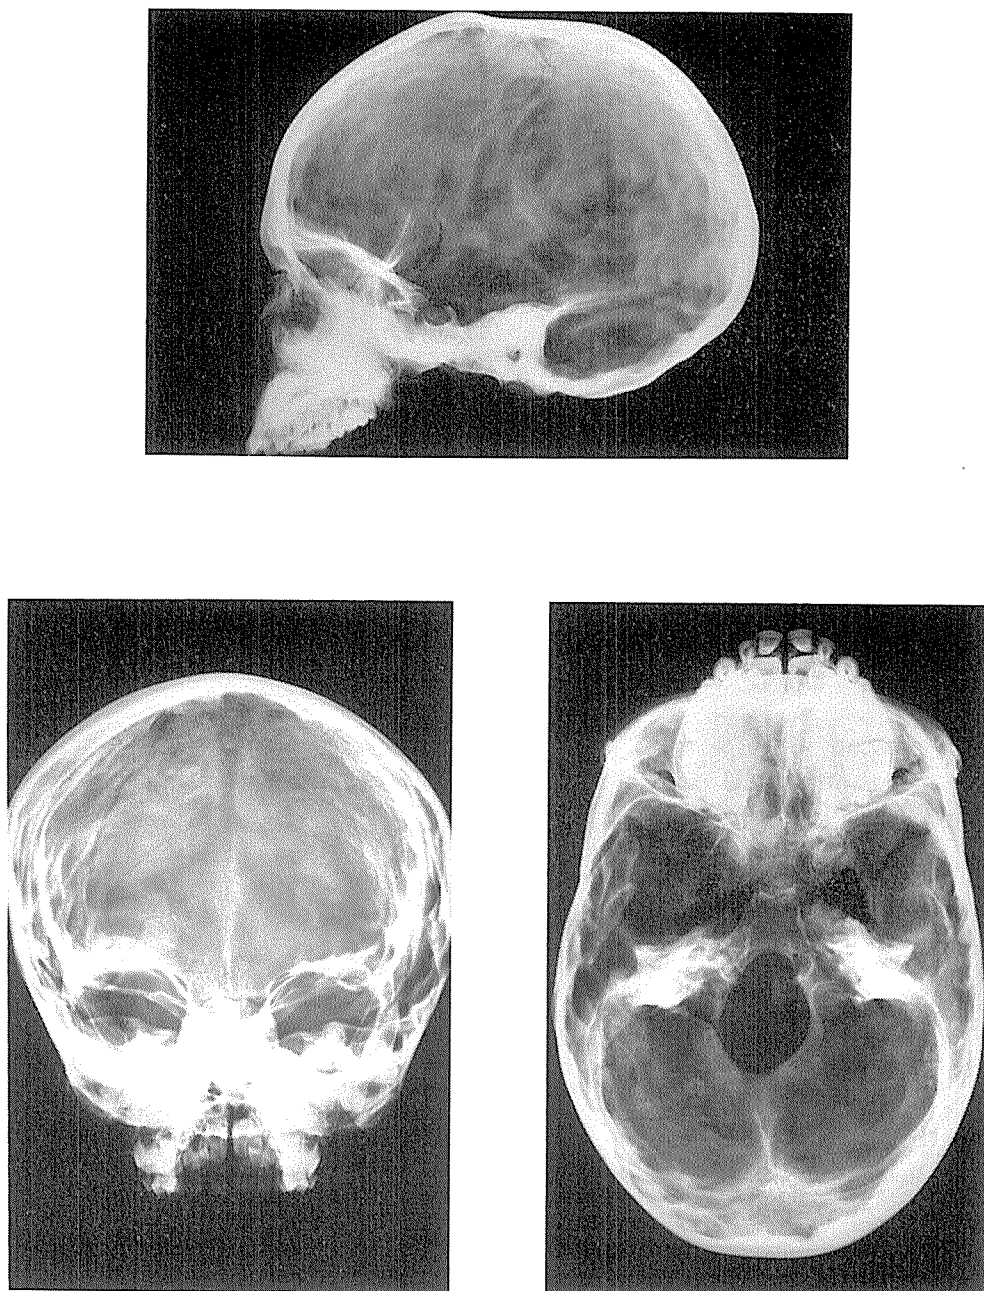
Radiographs of the same skull:
